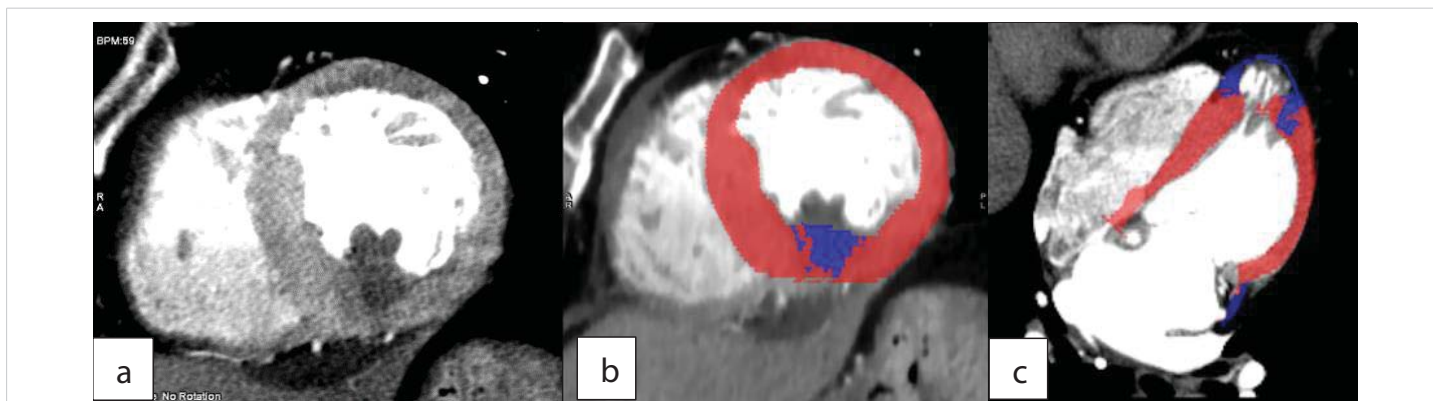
a-b: Short-axis CTCA and short-axis CT myocardial perfusion images with a color-coded map show hypoperfusion (blue color) of the infero-posterior wall, corresponding with the vascular territory of the coronary artery involved by SCAD; c: Long-axis CT myocardial perfusion image with a color-coded map shows myocardial hypoperfusion (blue color) of the apical wall (site of aneurysm), corresponding with the vascular territory of the coronary arteries involved by the previous two SCAD of distal LAD and PLA.
